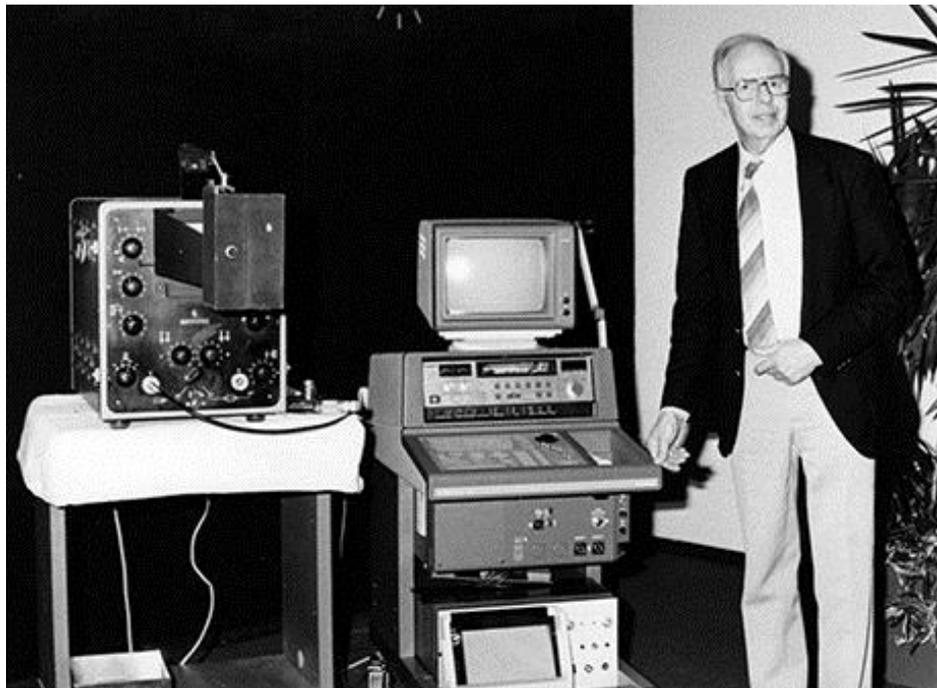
Hertz with the 1953 ultrasound reflectoscope on the left and the Sonoline CD on the right, 1985
